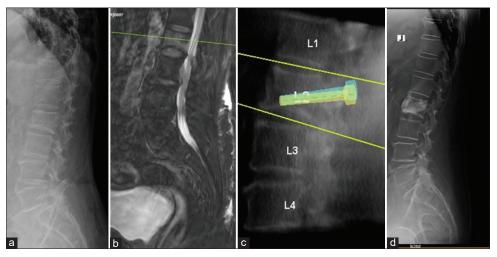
Preoperative radiograph and magnetic resonance imaging (a and b) of a patient with L2 inferior endplate fracture. The trajectory was directed to the site of fracture (c), postoperative radiographs showed no leak in cement into the canal (d)
